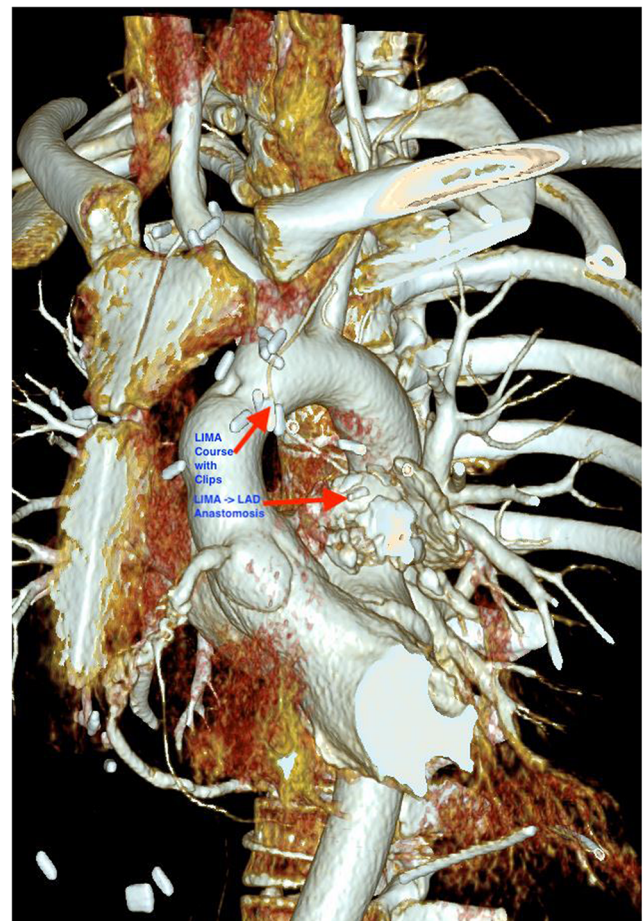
3D reconstructed postoperative CT angiogram showing patent LIMA->LAD anastomosis
